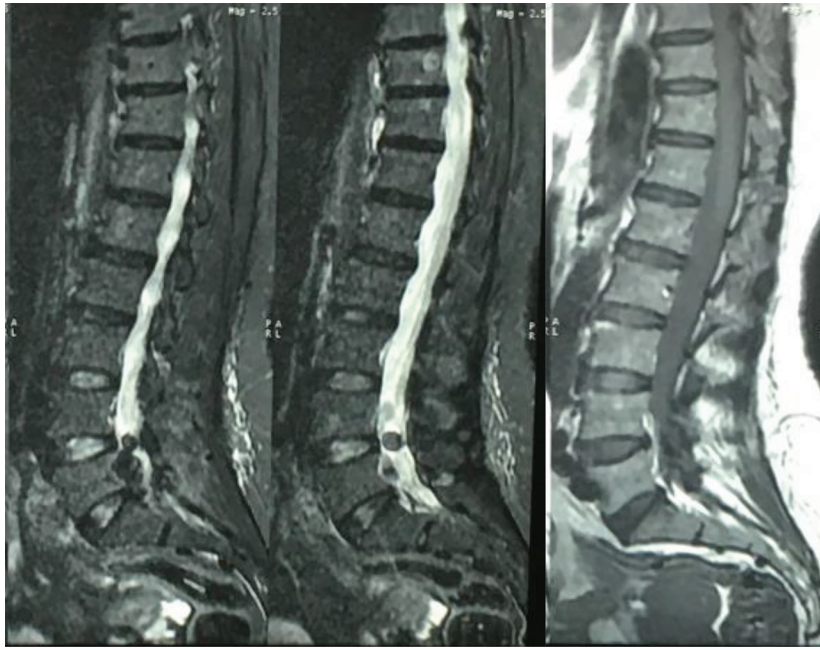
Sagittal MRI view of the lumbosacral area. The tumor is hypointense in T1 and T2 images. MRI, magnetic resonance imaging.
